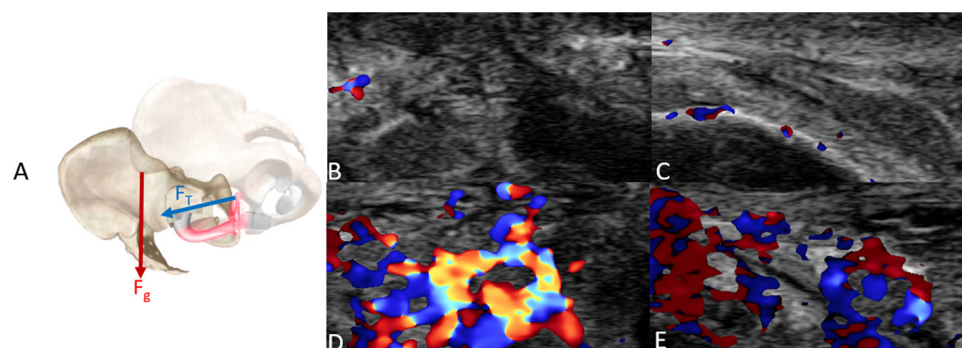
Biomechanical model of the sitting/face-to-face position (a). Both partners apply a thrusting force ( $F_T$ ) in opposite directions, which are both perpendicular to the female and male pelvis gravitational force ( $F_g$ ). Transverse and sagittal views of the clitoris before (b and c) and after (d and e) engaging in the sitting/face-to-face position, with color Doppler flow.
